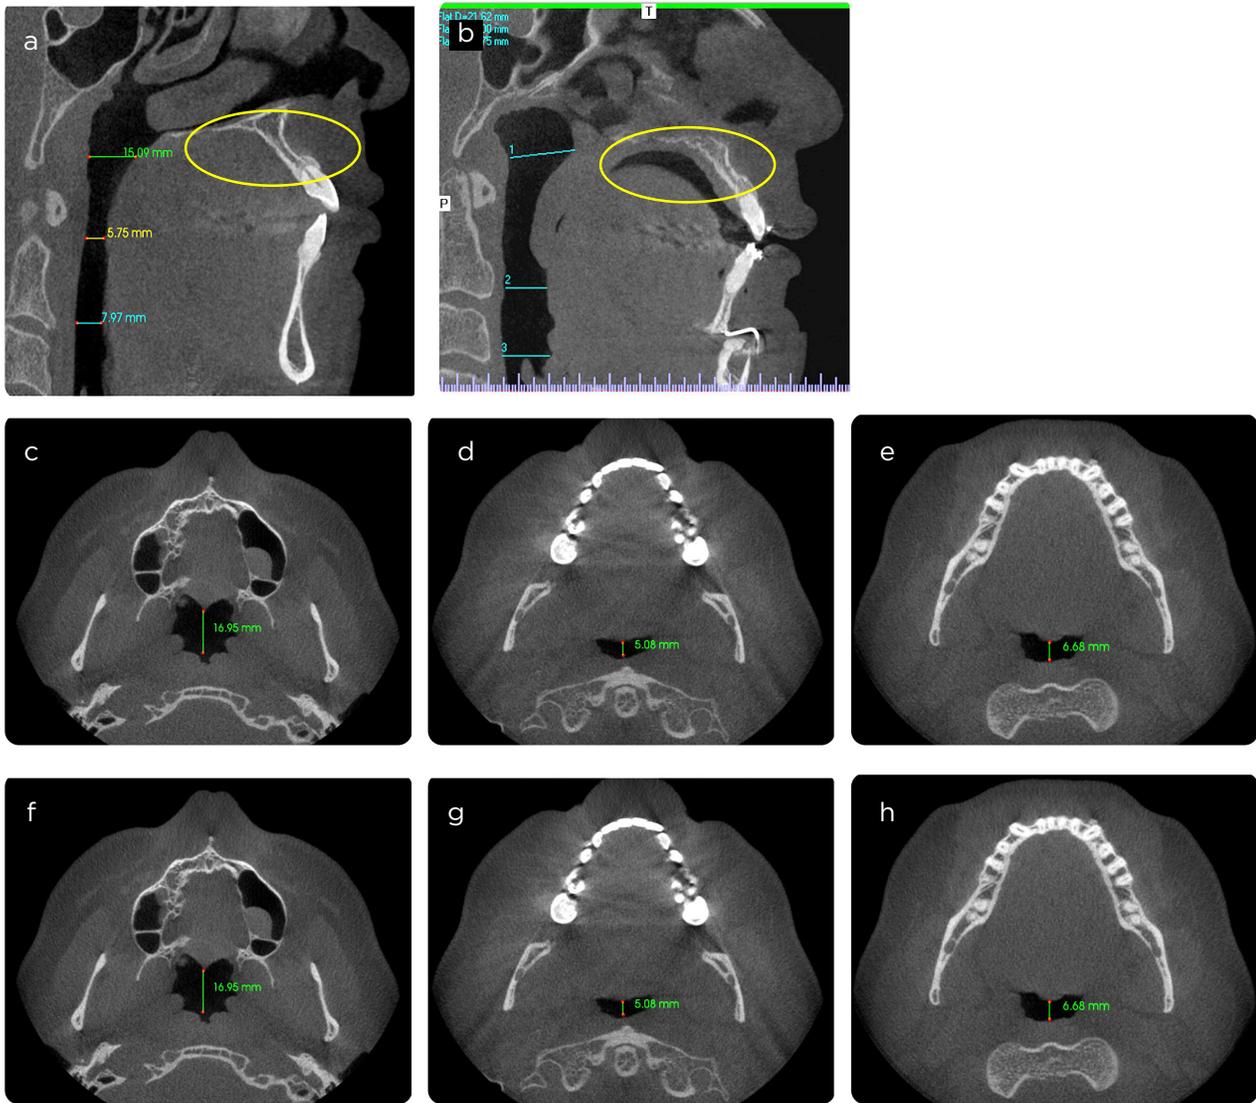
Patient undergoing MMA surgery. a) Pre-surgical patient, sagittal CT neck reconstruction, with airway measurements (green, yellow and blue lines). The space available for the position of the tongue is visualized (orange circle) where it is observed that the tongue, not having space due to the anatomical alteration, moves dorsally obstructing the airway. b) Post-surgical patient, sagittal CT neck reconstruction. There is an increase in the diameters of the airway and the space for the position of the tongue; the air column not previously visualized in this location can be seen (Orange circle). c-e) Pre-surgical patient. Axial CT acquisition of the neck with airway measurements at three levels. f-h). Post-surgical patient. Axial acquisition of neck CT: increased airway diameters at different levels are observed.
